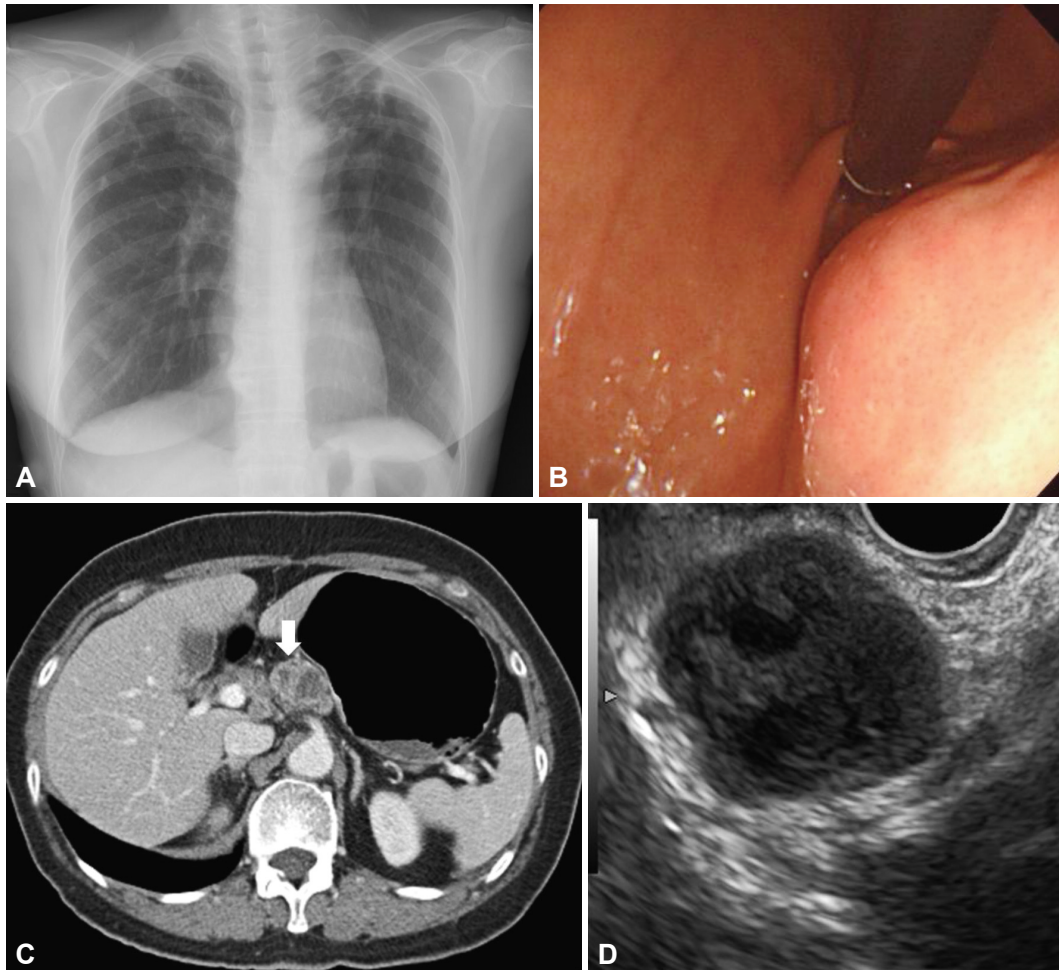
Clinical findings. (A) Chest X-ray showing multiple variably sized calcified nodules in both upper lobes. (B) Upper endoscopy showing a 3×3 cm intraluminal protruding mass with normal overlying mucosa in the cardiac region of the lesser curvature of the stomach. (C) Abdominal computed tomography showing enlarged lymph nodes with rim enhancement and central low attenuation at the gastrohepatic ligament. (D) Endoscopic ultrasonography showing an enlarged heterogeneous hypoechoic lymph node.
